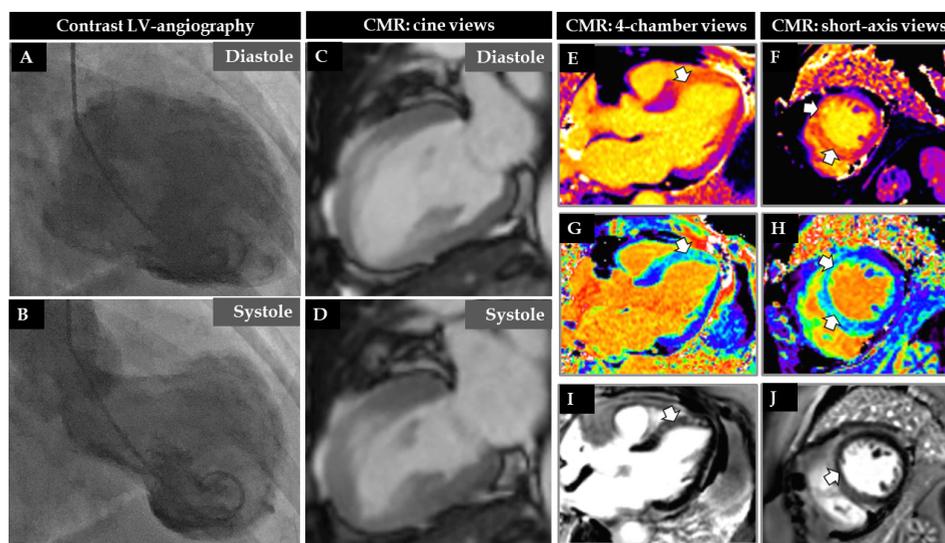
Invasive left ventriculogram and cardiac magnetic resonance imaging (CMR) in a middle-aged woman presenting with chest pain after a stressful situation. Coronary angiogram on admission revealed normal left and right coronary arteries. Invasive left ventriculogram demonstrated typical mid-apical takotsubo syndrome (TTS) with an apical tip-sparing pattern (A, B). Cardiac MRI 3 days after admission demonstrated mild improvement in left ventricular function particularly in the apical region in cine images (C, D). Native T1 mapping demonstrated significant increases in T1 values in the mid-apical regions particularly in the septal and anterior segments [(E, F), white arrows]. Extracellular volume (ECV) mapping also demonstrated significant increases in ECV values representing myocardial edema in the corresponding areas [(G, H), white arrows]. Images of late gadolinium enhancement were consistent with an increased transmural signal intensity (but no infarction changes) in the mid-apical region particularly the septal segment [(I, J), white arrows]. Consequently, this demonstrates “myocarditis-like” changes in the mid-apical (septal and anterior segments) in a typical case of TTS.
